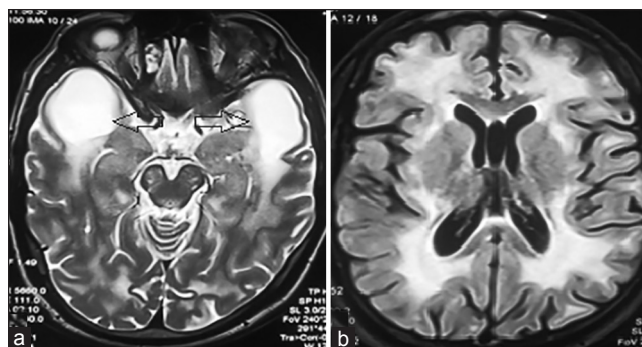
Magnetic resonance imaging brain (a and b) Axial T1 weighted and T2-weighted images show subcortical cysts (arrows) in the bilateral anterior temporal lobes.
